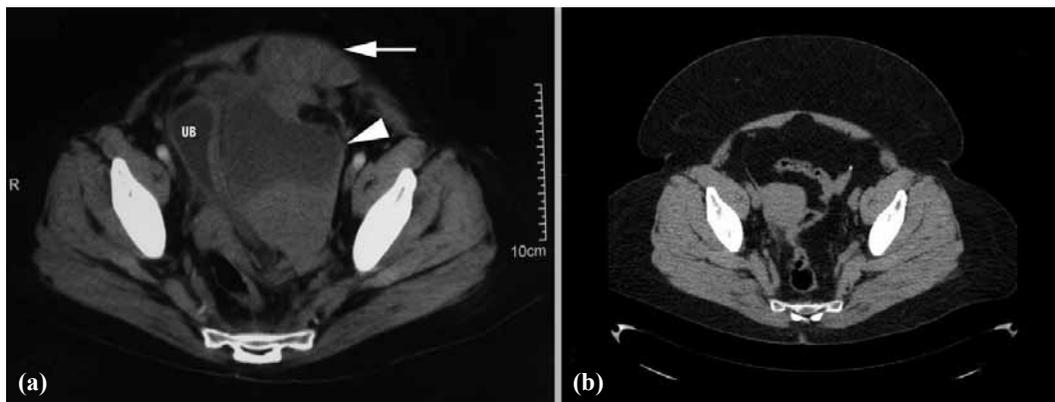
The abdominal CT appearance of spontaneous RSH in a female patient who had been taking warfarin prior to hospital admission (a). The hematoma arose from the left rectus muscle (arrow). The urinary bladder (UB) was shifted to the right with the expansion of the hematoma to the intraperitoneal cavity (arrowhead). Following conservative treatment, complete resolution of the hematoma was seen on follow-up CT after 12 months (b).
